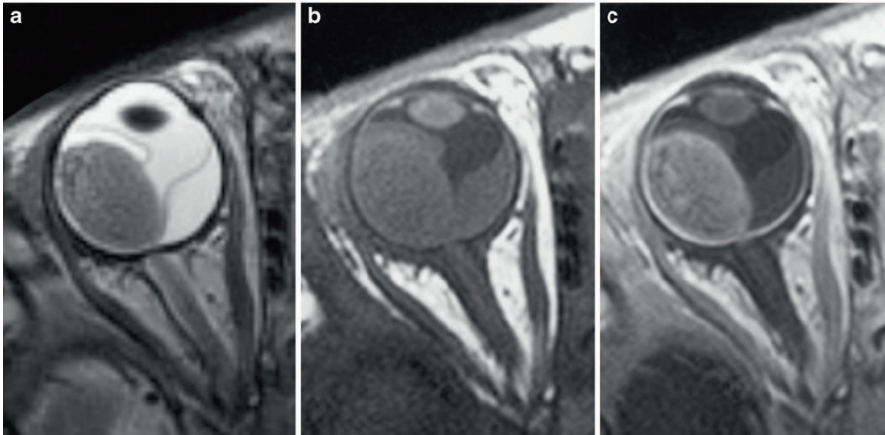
Transaxial T2-weighted (TR/TE, 3,460/116 ms) (a) and T1-weighted (TR/TE, 374/14 ms) Precontrast (b) and postcontrast (c) MRI of exophytically growing retinoblastoma with secondary retinal detachment. Retinoblastoma typically has low signal intensity Fig. 3 Transaxial T2-weighted (TR/TE, 3,460/116 ms) (a) and T1-weighted (TR/TE, 374/14 ms) precontrast (b) and postcontrast (c) MRI of exophytically growing retinoblastoma with secondary retinal detachment. Retinoblastoma typically has low signal intensity
